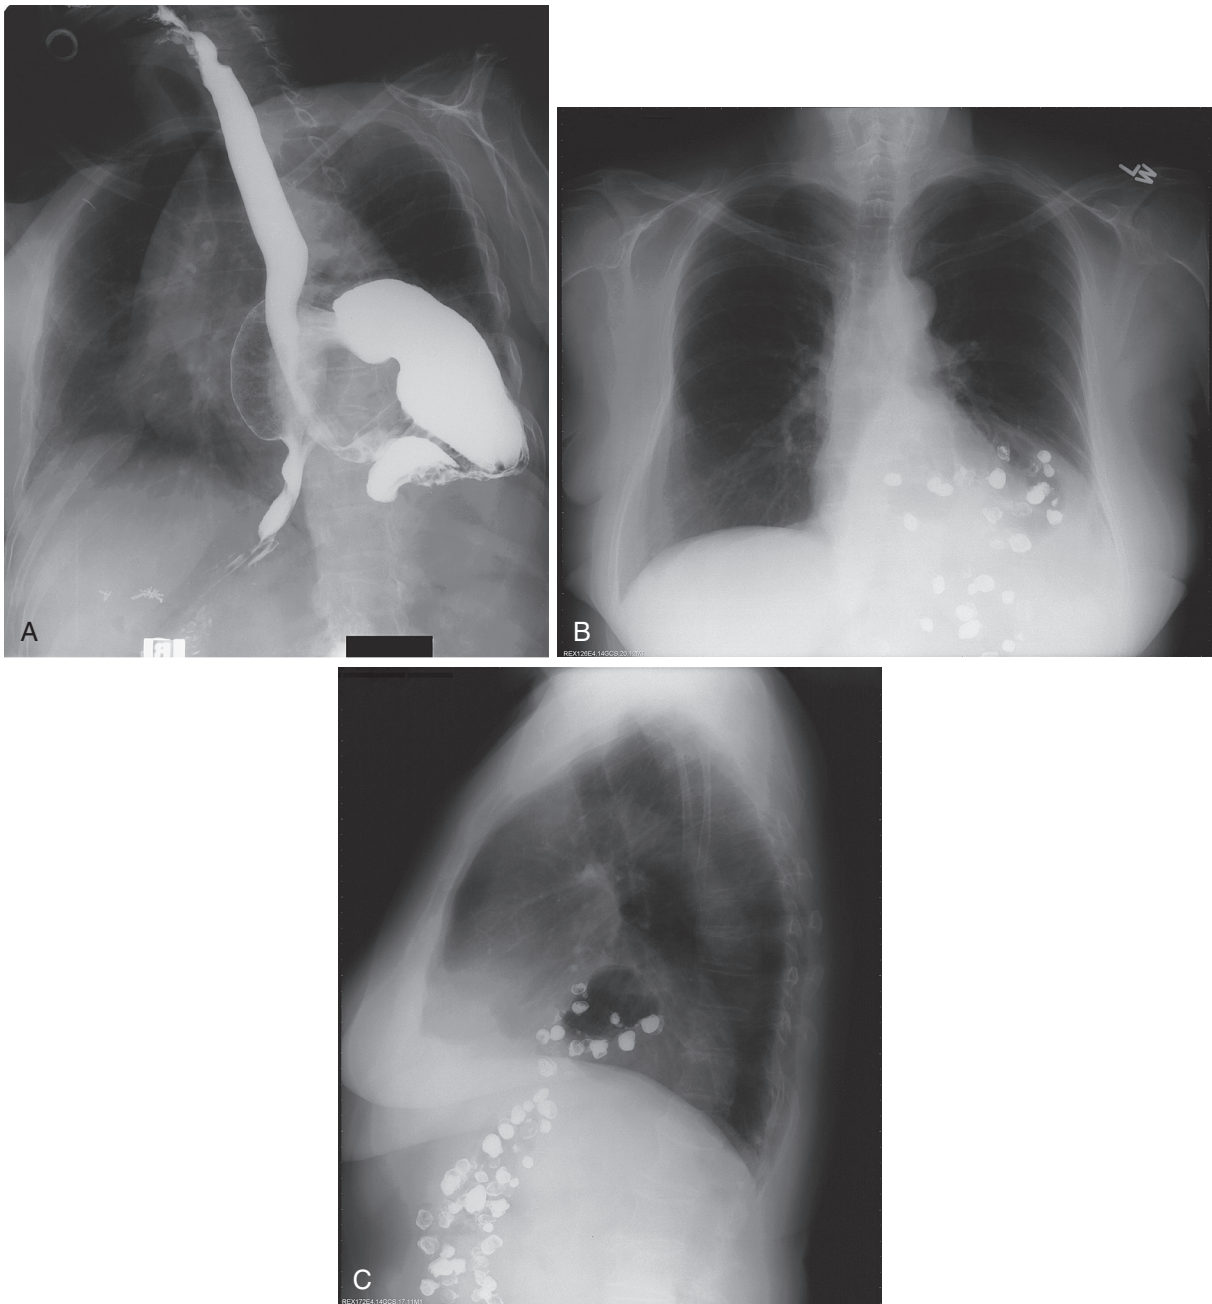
■ Type IV hiatal hernia. A, Barium esophagram demonstrates a type III hiatal hernia with organoaxial rotation. Three days later, barium is seen in colonic diverticulum on preoperative chest radiograph. B, Posteroanterior view. C, Lateral view. Therefore, this is a type IV hiatal hernia.
